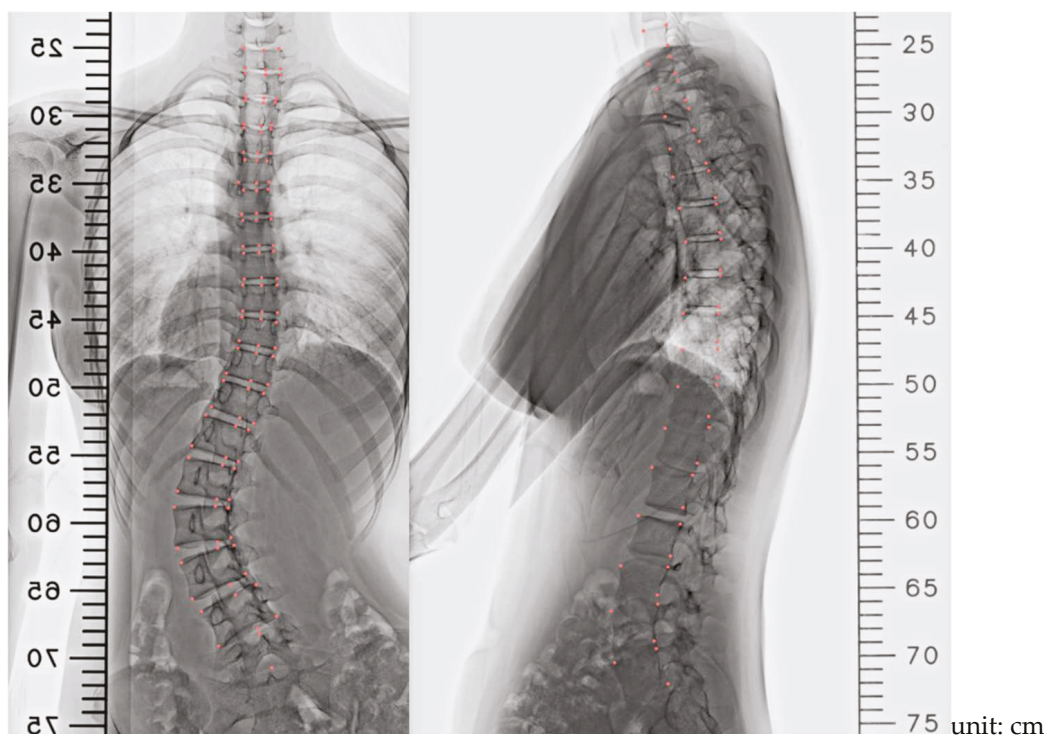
X-ray image parameters were obtained with a 3D Slicer in PA view and lateral view. Note: Pink markers indicate sampling points.
